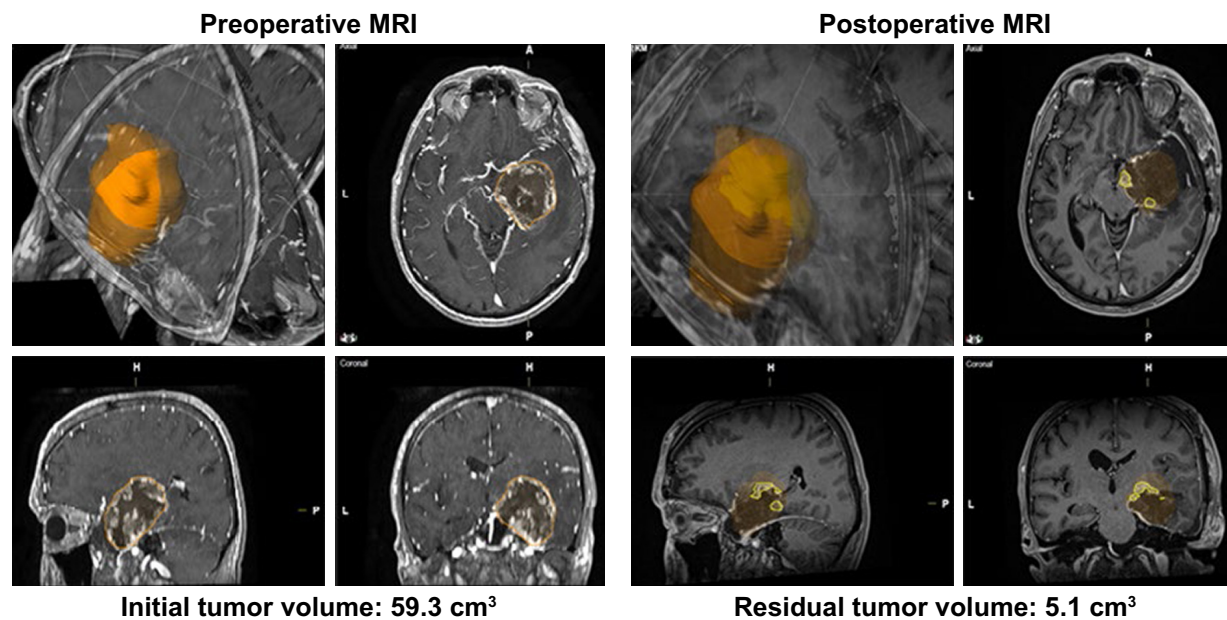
Volumetric assessment of EOR. Example of 60-year-old patient suffering from a large, highly vascularized, space-occupying *IDH*-wildtype, *MGMT* unmethylated glioblastoma of the right mesio-temporal lobe with critical involvement of the basal ganglia and compression of the midbrain. A subtotal resection of the almost spherical tumor formation (left side, highlighted in orange) has been achieved without perioperative morbidity. The postoperative control MRI confirmed an extensive resection with sufficient decompression of vulnerable structures and some minor complex shaped, multifocal tumor remnants (yellow). The respective volumes were calculated using a semiautomatically three-dimensional calculation tool (SmartBrush®, Brainlab, Feldkirchen, Germany) indicating an EOR of 91.4%.
